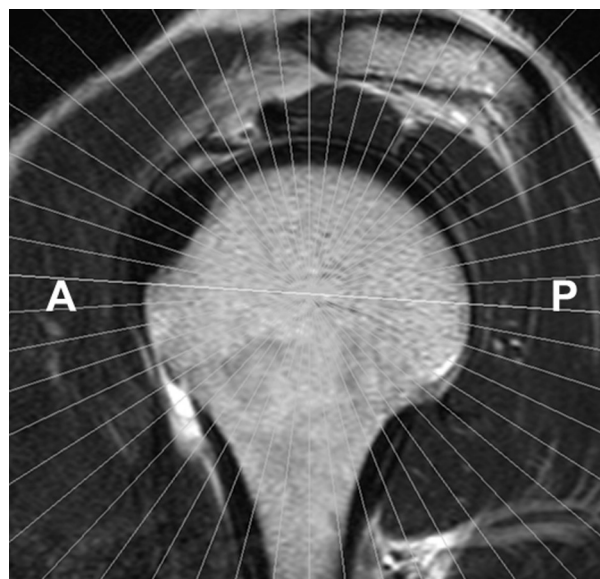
Radial-slice MR image plane. All slices were based on a reference image on which the sagittal plane was positioned parallel to the glenoid fossa of the scapula, with a total of 24 slices acquired at 7.5° intervals around a rotation axis formed by the line connecting the midpoints of the glenoid fossa and humeral head. A, anterior; P, posterior.
